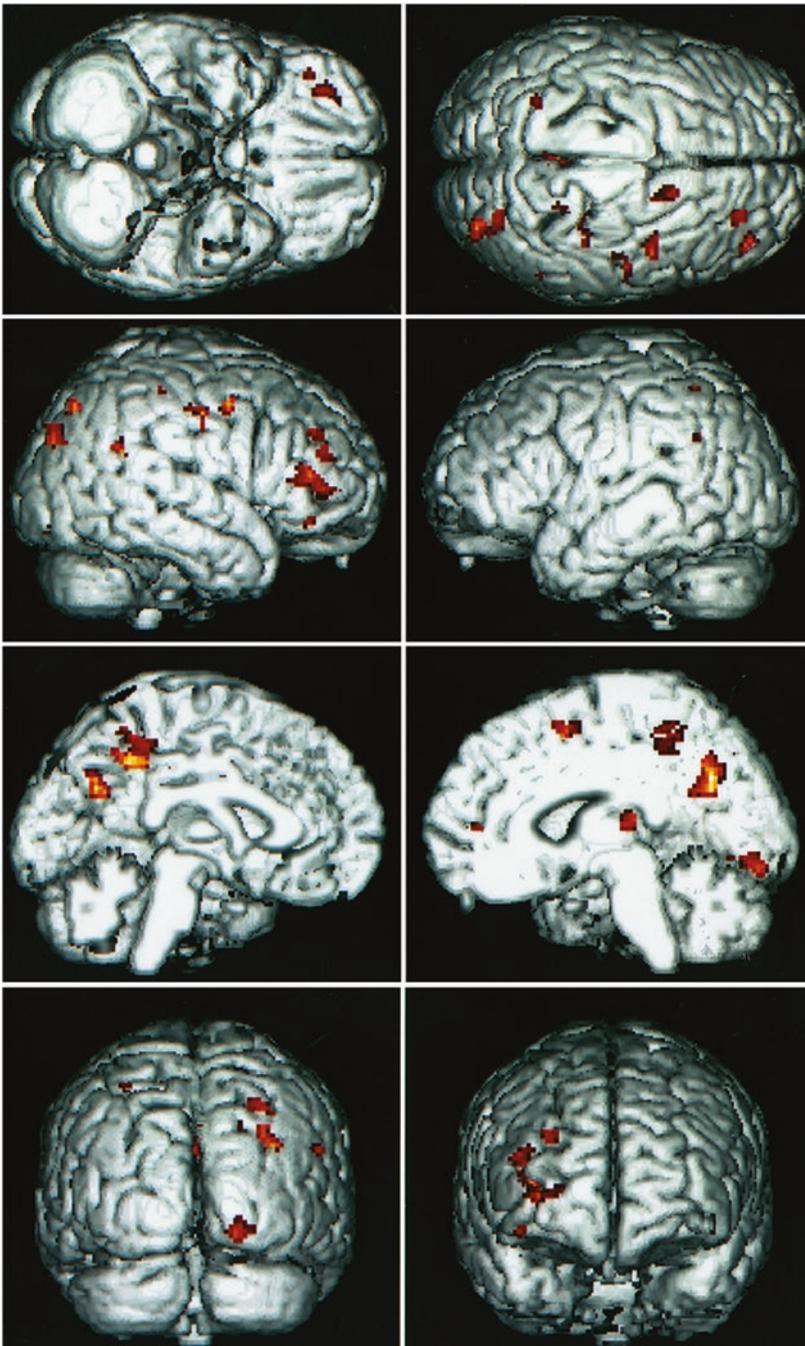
FDG-PET SPM image of a patient after bicycle accident showing a marked reduction of glucose utilization in the right frontal, parietal, and occipital region of the brain. (This figure was published in Otte et al. (1998b), copyright Elsevier (1998). With kind reproduction permission from Elsevier Ltd.)
